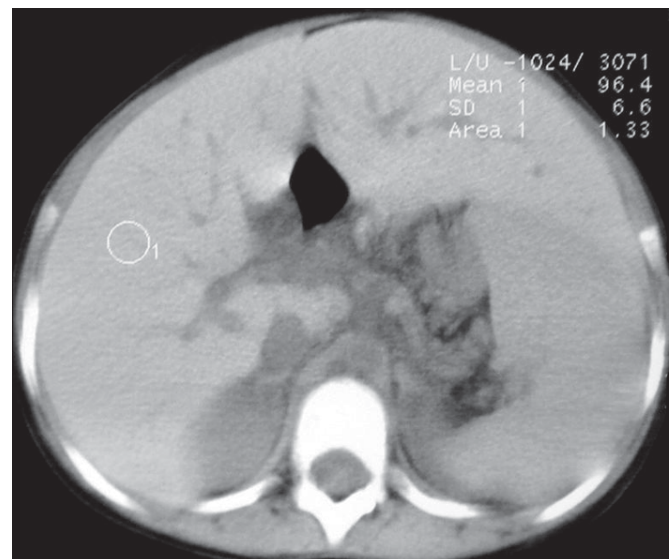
Non-contrast CT shows that attenuation of the liver is more than that of the spleen. The measured mean Hounsfield units value is 96, suggestive of a diagnosis of haemochromatosis.
